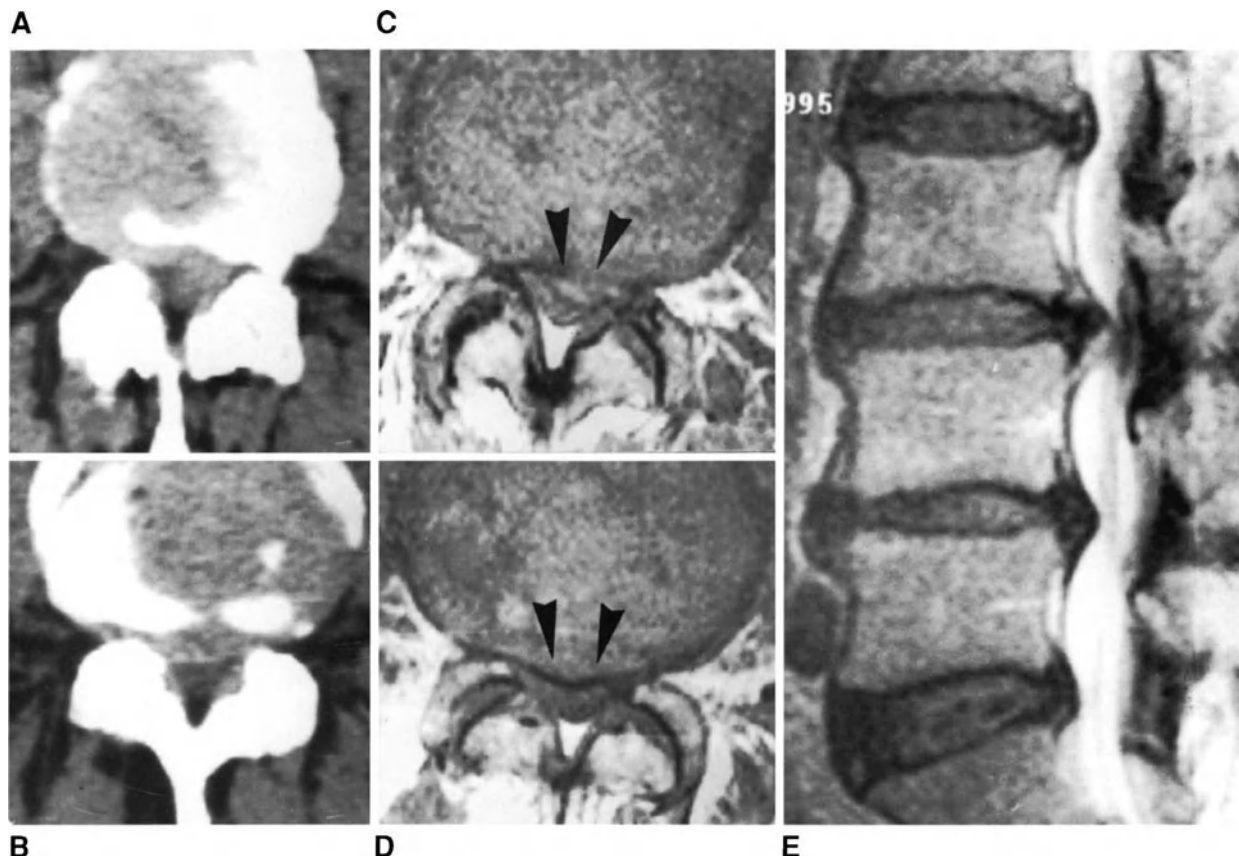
Multiple disc herniations in a patient with mild constitutional stenosis of the spinal canal. On CT scans at L3-L4 and L4-L5 levels (A) and (B), the image of the thecal sac is hardly distinguishable from that of the disc herniation. On the spin-echo T1-weighted axial MR images at the same levels (C) and (D), the thecal sac compressed by the disc herniations (arrowheads) and narrowing of the spinal canal are clearly visible. The pathologic conditions are even better evident on the turbo spin-echo T2-weighted sagittal image (E).
